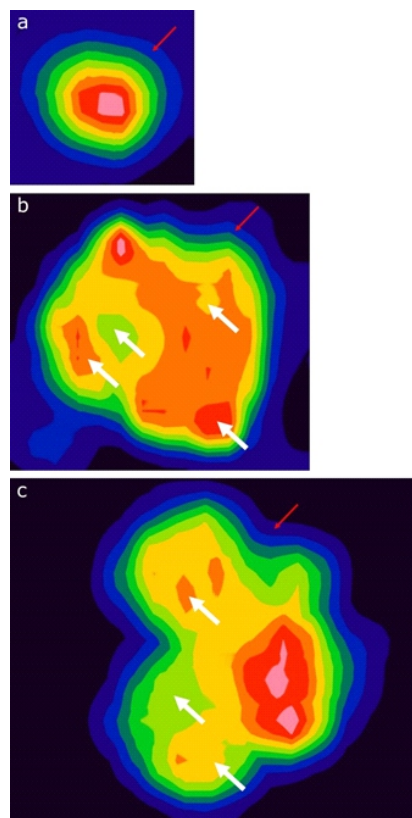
Representative tumors for three visual patterns. a) Visually homogenous tumor. The cold defect is not visible, and central hottest core can be confirmed. Regular margins are observed in all tumor layers. The PHL layer (red arrow, 20% of SUVmax) is located between tumor and background activity. b) Visually heterogeneous tumor. The cold defect is observed, and the hottest core is located in the eccentric portion. Four irregular layers (white arrow) are visually observed. The PHL layer is located in 20% of SUVmax (red arrow). c) Visually heterogeneous tumor. Cold defect is not visible, and the hottest core is in peripheral. Three irregular layers (white arrow) are observed, and the PHL layer is located in 10% of SUVmax (red arrow).
